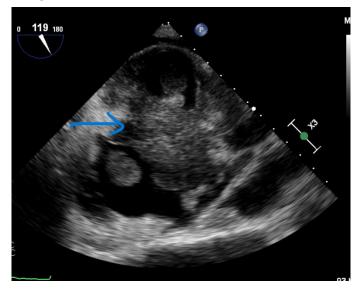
On transeusophageal echocardiography a giant mass observed . Invaded the both atria and superior vena cava.
